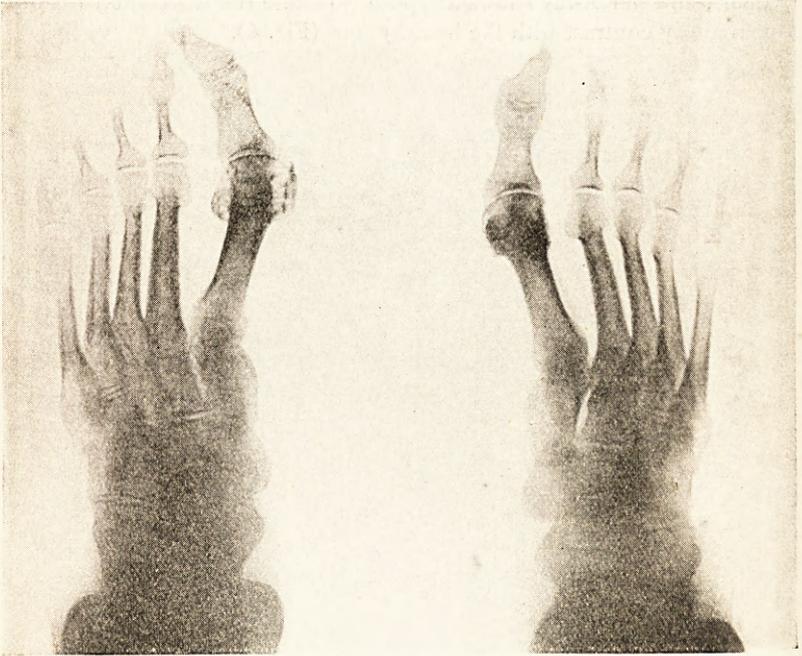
Case V. (Mrs H.). X-ray of feet, showing osteodystrophy of left tarsus and metatarsus following scalding three months previously.
